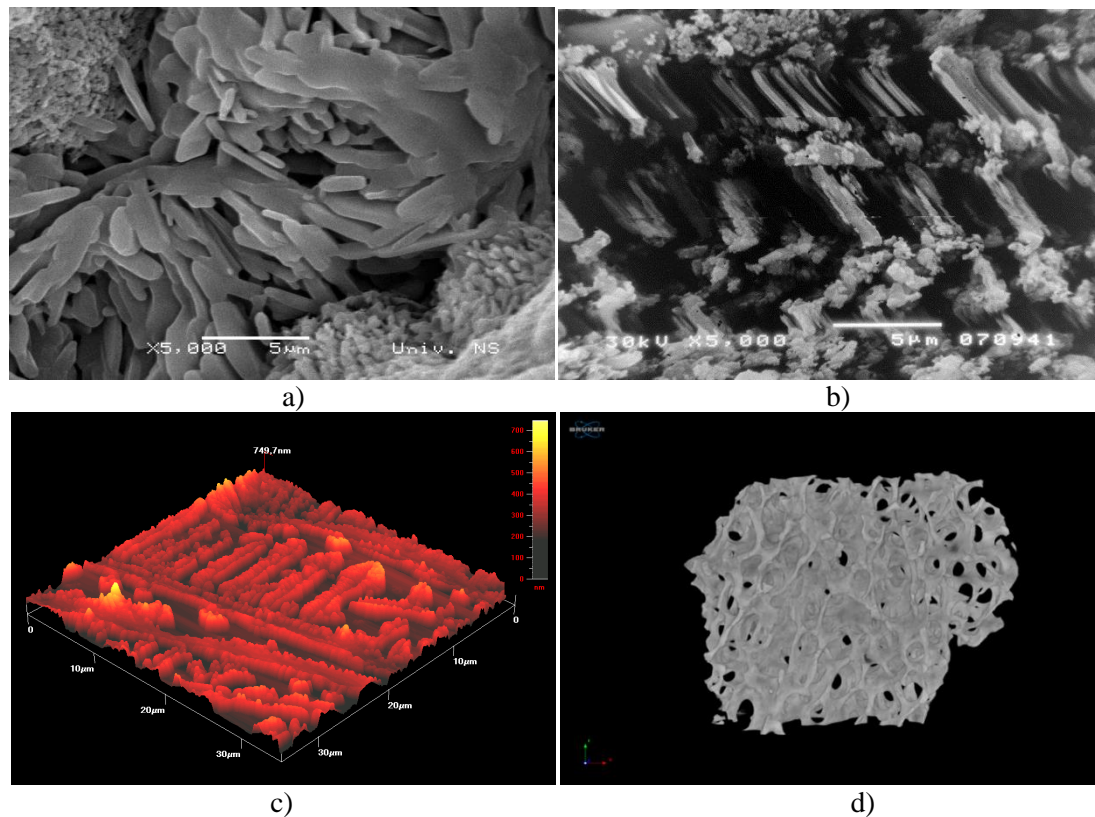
Typical appearance of scaffold structure for bone repairing: a) and b) SEM pictures show large number of voids and scaffold walls built of lamellas, length more then 5 μm ; c) AFM show comb like channel structure length 30 μm , width 3 μm branches with wall thickness 3-5 μm and pronounced orientation caused by template wall orientation; d) Computed tomography of scaffold structure
